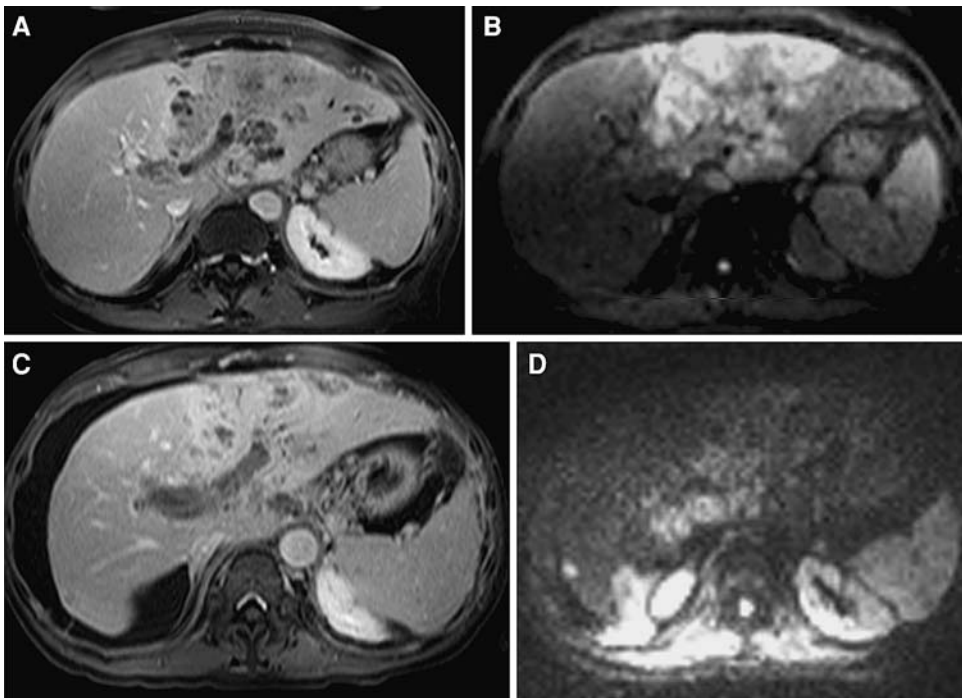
(A) Pre-treatment gadolinium-enhanced MRI shows a large heterogeneous mass in the left lobe of the liver. The margins are difficult to define. (B) Pre-treatment DW-MRI differentiates the tumor from the surrounding liver. The tumor has restricted diffusion and the margins are well defined. (C) Post-treatment gadolinium-enhanced MRI shows enhancement of the left lobe of the liver. It is difficult to assess response as the tumor is not well defined. (D) Post-treatment DW-MRI shows a response with the mass showing less restricted diffusion and appearing significantly smaller. A new lesion is seen in the right lobe of the liver.
